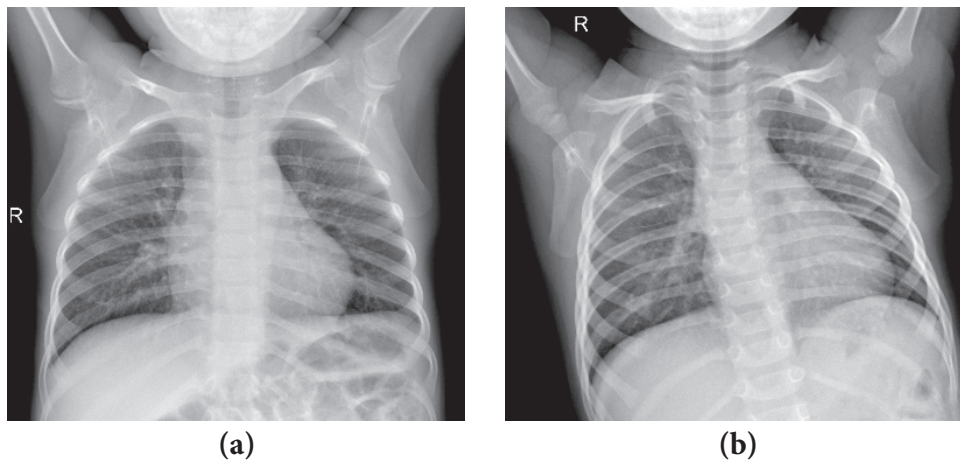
Chest X-ray images (a) Arm and neck limbs (b) Posture disorder.
